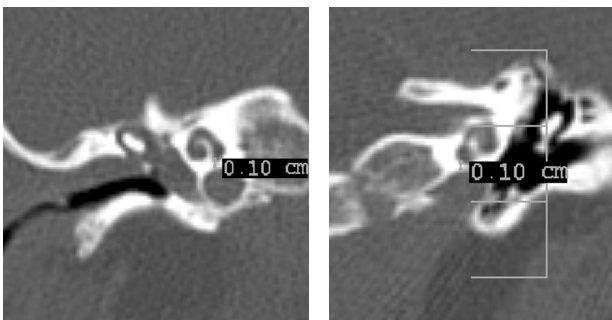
a and b: Coronal HRCT of the temporal bone. In this patient, the distance between the carotid canal and the basal turn of cochlea (CCI) is 1.0 mm on both sides
